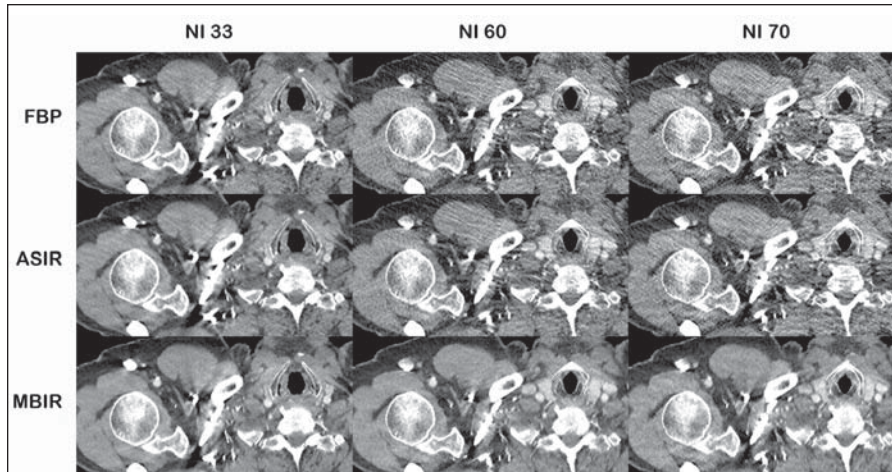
73-year-old woman undergoing CT for follow-up breast cancer surveillance. Transverse chest CT images show soft-tissue structures in upper chest. Note noisier images with filtered back projection (FBP) and adaptive statistical iterative reconstruction (ASIR) compared with model-based iterative reconstruction (MBIR). NI = noise index.
